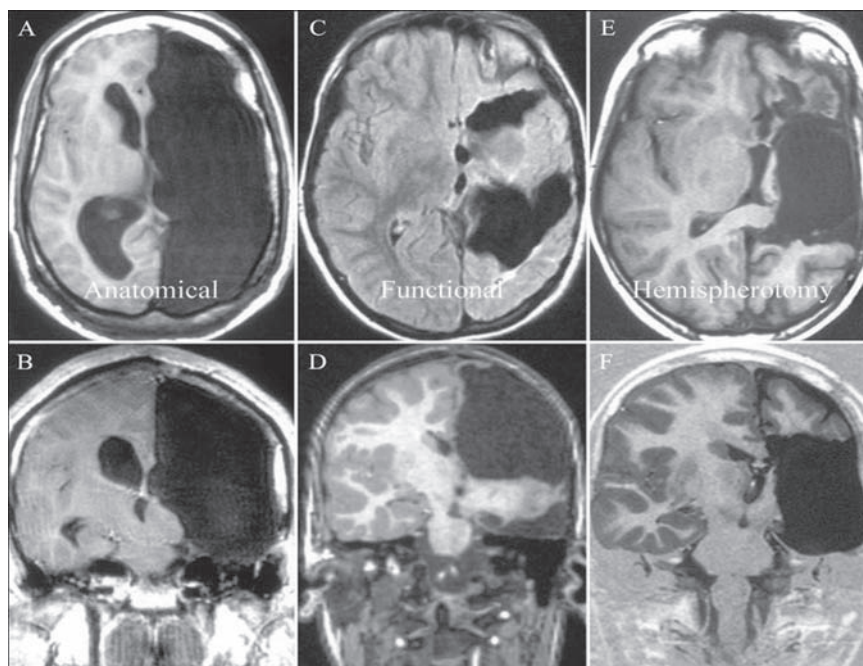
Hemispherectomy. T1-Weighted MRI scans of examples of anatomical (A and B) and functional (C and D) hemispherectomy, and hemispherotomy (E and F)
